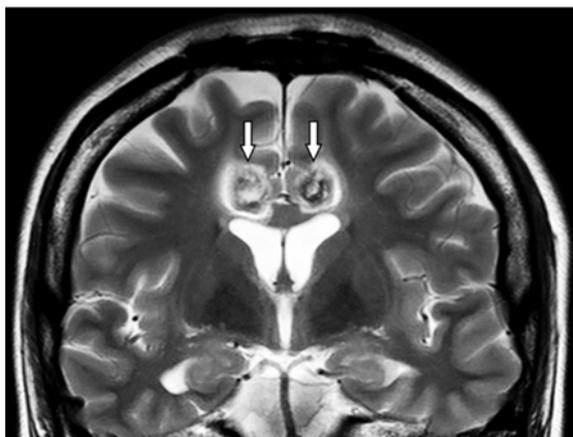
Coronal MRI of the brain after anterior cingulotomy showing lesions at the anterior cingulate gyri (arrows).
